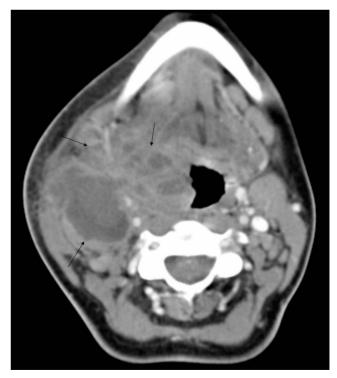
Axial contrast-enhanced CT showing a multiseptated abscess (black arrows) occupying multiple spaces arising from untreated tonsillitis.
